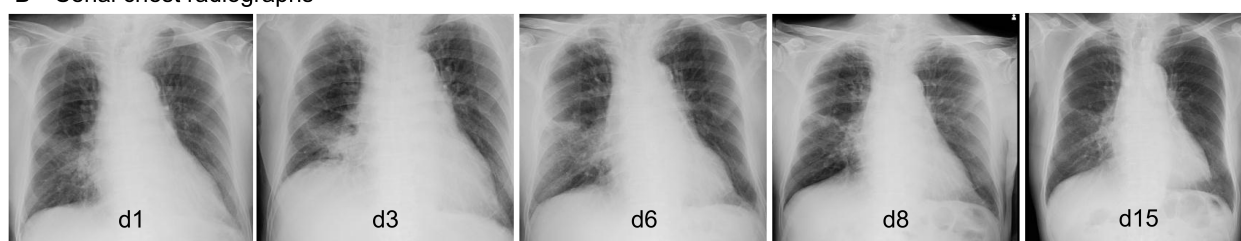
Clinical course and chest radiographs of a patient with pneumonia. (A) Clinical course showing changes in peripheral oxygen saturation, white blood cell count, and C-reactive protein level after initiation of remdesivir, ceftriaxone, and levofloxacin. (B) Serial chest radiographs showing gradual improvement of pulmonary infiltrates. CRP: C-reactive protein; CTRX: ceftriaxone; LVFX: levofloxacin; SpO₂: peripheral oxygen saturation; WBC: white blood cell count.
